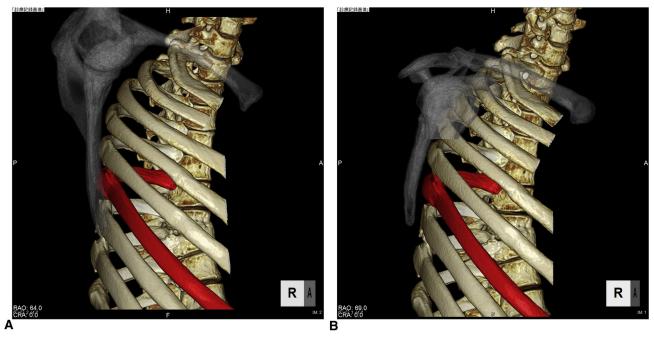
Three-dimensional computed tomography of the snapping scapula. A bulging fracture site in the 6th rib (shown in red) blocked the motion of the medial scapular edge in the abductor position of the right upper limb (A), whereas the blockage was relieved in the adductor position (B).
